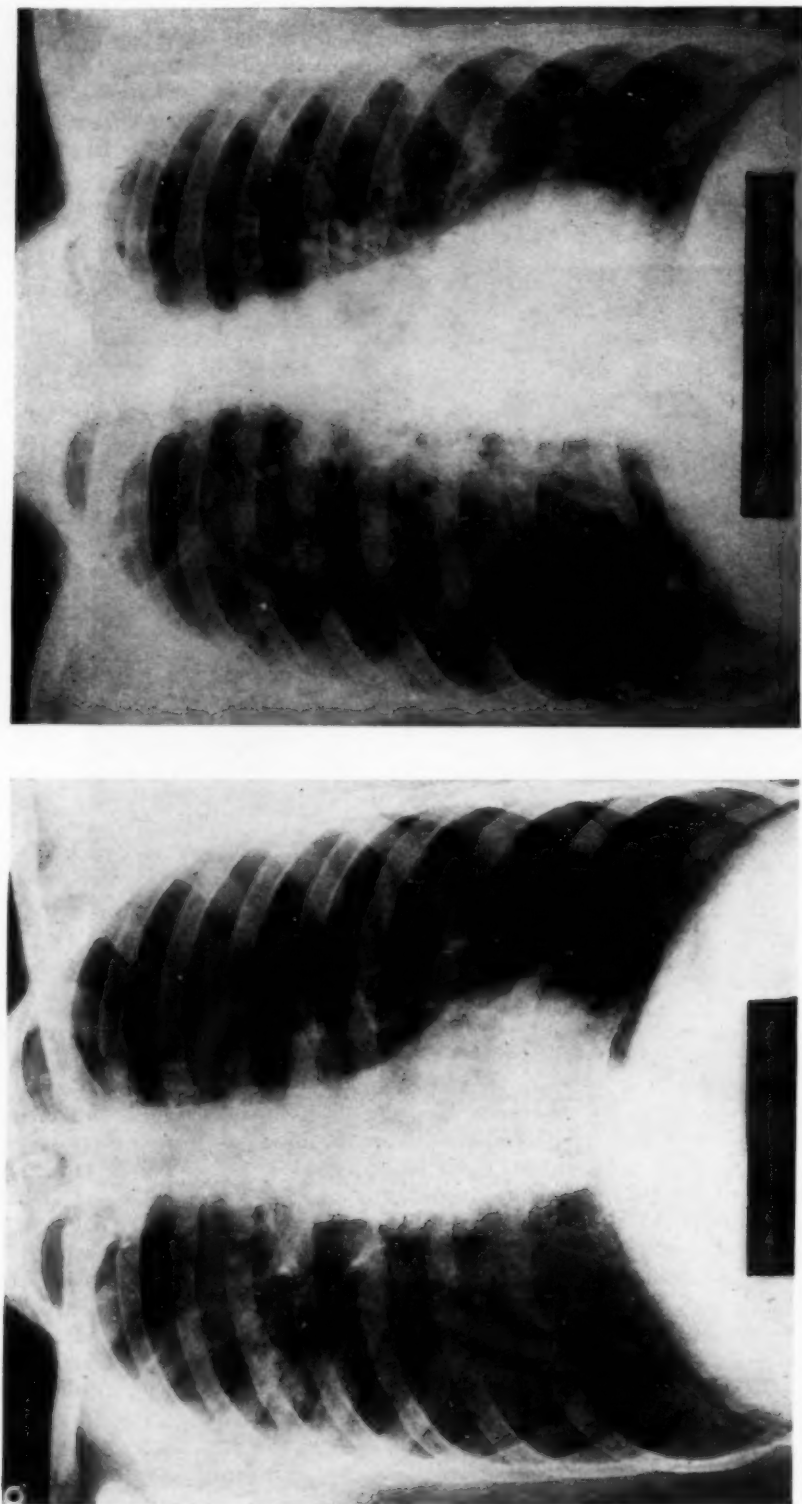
Chest roentgenogram of patient 264, R. T., before and following induction of right pneumothorax. Findings before pneumothorax for right lung in per cent of total. Oxygen intake: 29; tidal air: 50; vital capacity: 50. After induction of pneumothorax, oxygen intake: 44; tidal air: 46; vital capacity: 33.
